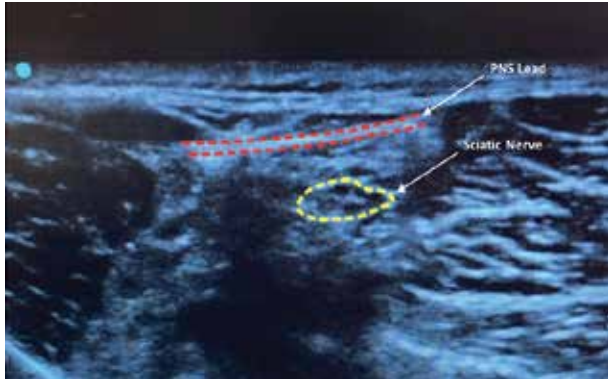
Lead placement proximal to the sciatic nerve bifurcation using ultrasound guidance.
